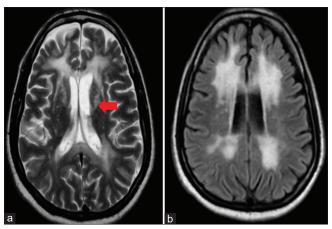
Imaging MRI of the case report (a) T2 AXIAL: Confluent symmetrical hyperintensities noted in the periventricular and subcortical white matter of bilateral frontal and parietal lobe, T2 hyperintensity is noted involving anterior limb of internal capsule (Red arrow) and anterior part of corpus callosum; (b) FLAIR AXIAL image showing confluent hyperintensities in the periventricular region. Source: Author's own work
